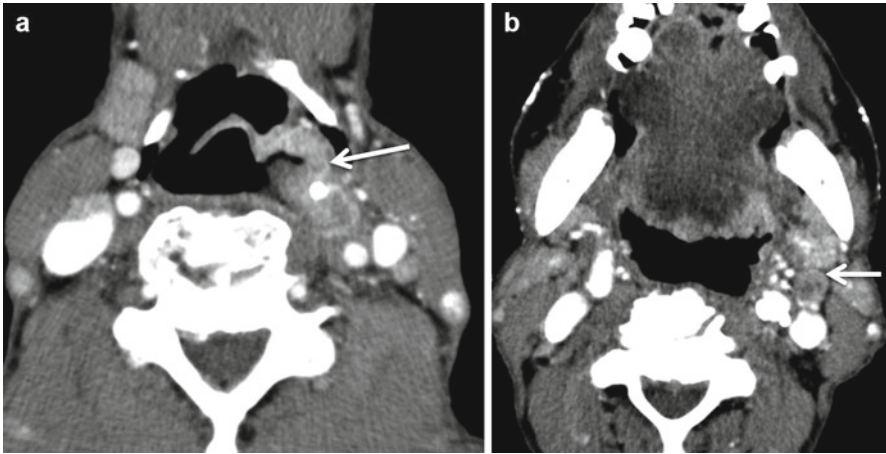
Contrast-enhanced CT (a) in a patient with sinonasal tumor demonstrates bilateral necrotic retropharyngeal nodes (*arrows*). Another 55-year-old patient (b) with tonsillar cancer (*star*) has a pathological 1 cm right retropharyngeal node (*arrow*)
